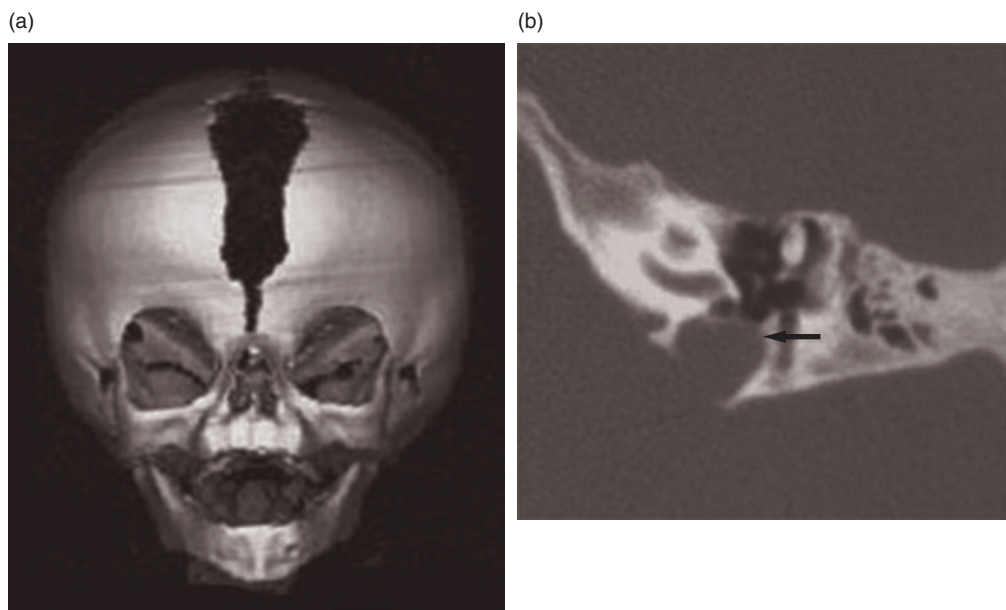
Crouzon syndrome. (a) Skull 3D-CT: craniosynostosis with abnormal dilation of the bregmatic fontanel and metopic suture. (b) Axial CT scan: tympanic dehiscence of the jugular bulb (arrow) (reproduced from Calzolari F., 2006,⁶ with permission of Omega Edizioni).
